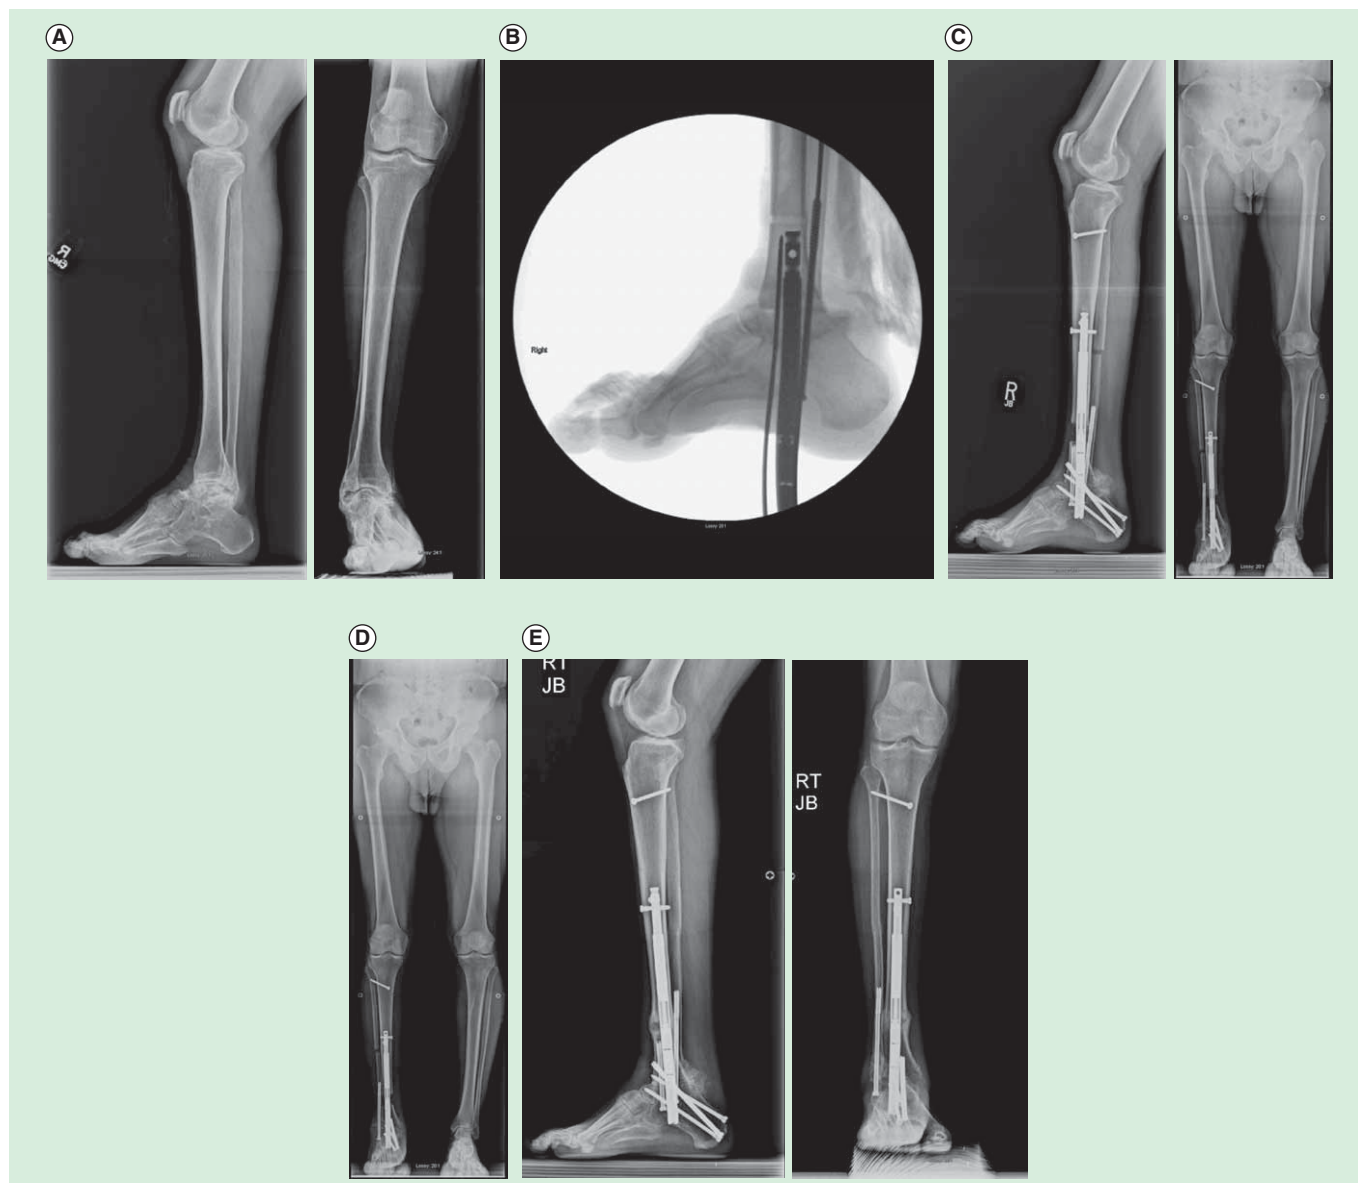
Fifty five year old man with ankle arthritis and pain. (A) Preoperative AP and lateral radiographs of the tibia, ankle and foot. (B) Intra-operative fluoroscopic picture of a lateral of the foot showing the ankle fusion and retrograde insertion of the first Precice2 in the US November 2013. (C) The distal tibia was lengthened 2.5 cm. (D) The ankle was fused and LLD equalized intentionally leaving a 1 cm discrepancy. (E) AP and lateral radiographs showing union of the ankle fusion and the distraction gap.
